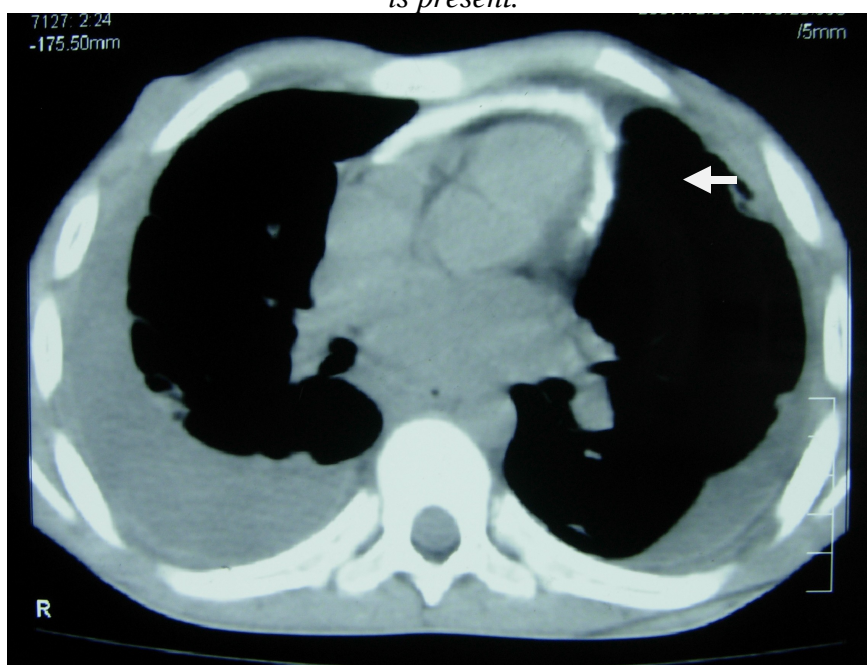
B Contrast enhanced CT chest showing thickened pericardium with calcification around RV, LV and LV apex.
